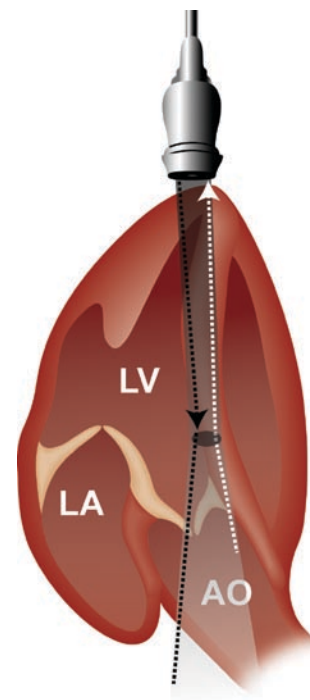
With the pulsed-wave Doppler (PWD), a single ultrasound crystal emits a short pulse of ultrasound and awaits its return before the following pulse is transmitted
